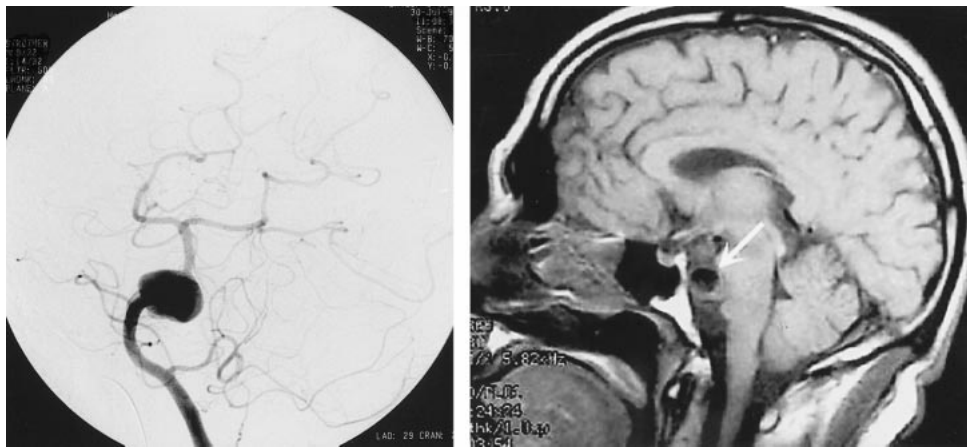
Preoperative digital subtraction angiogram (*left*) and sagittal view MR image of the brain (*right*) show a partially thrombosed fusiform midbasilar artery aneurysm (*arrows*). Note the dominant left vertebral artery supplying the basilar artery.
